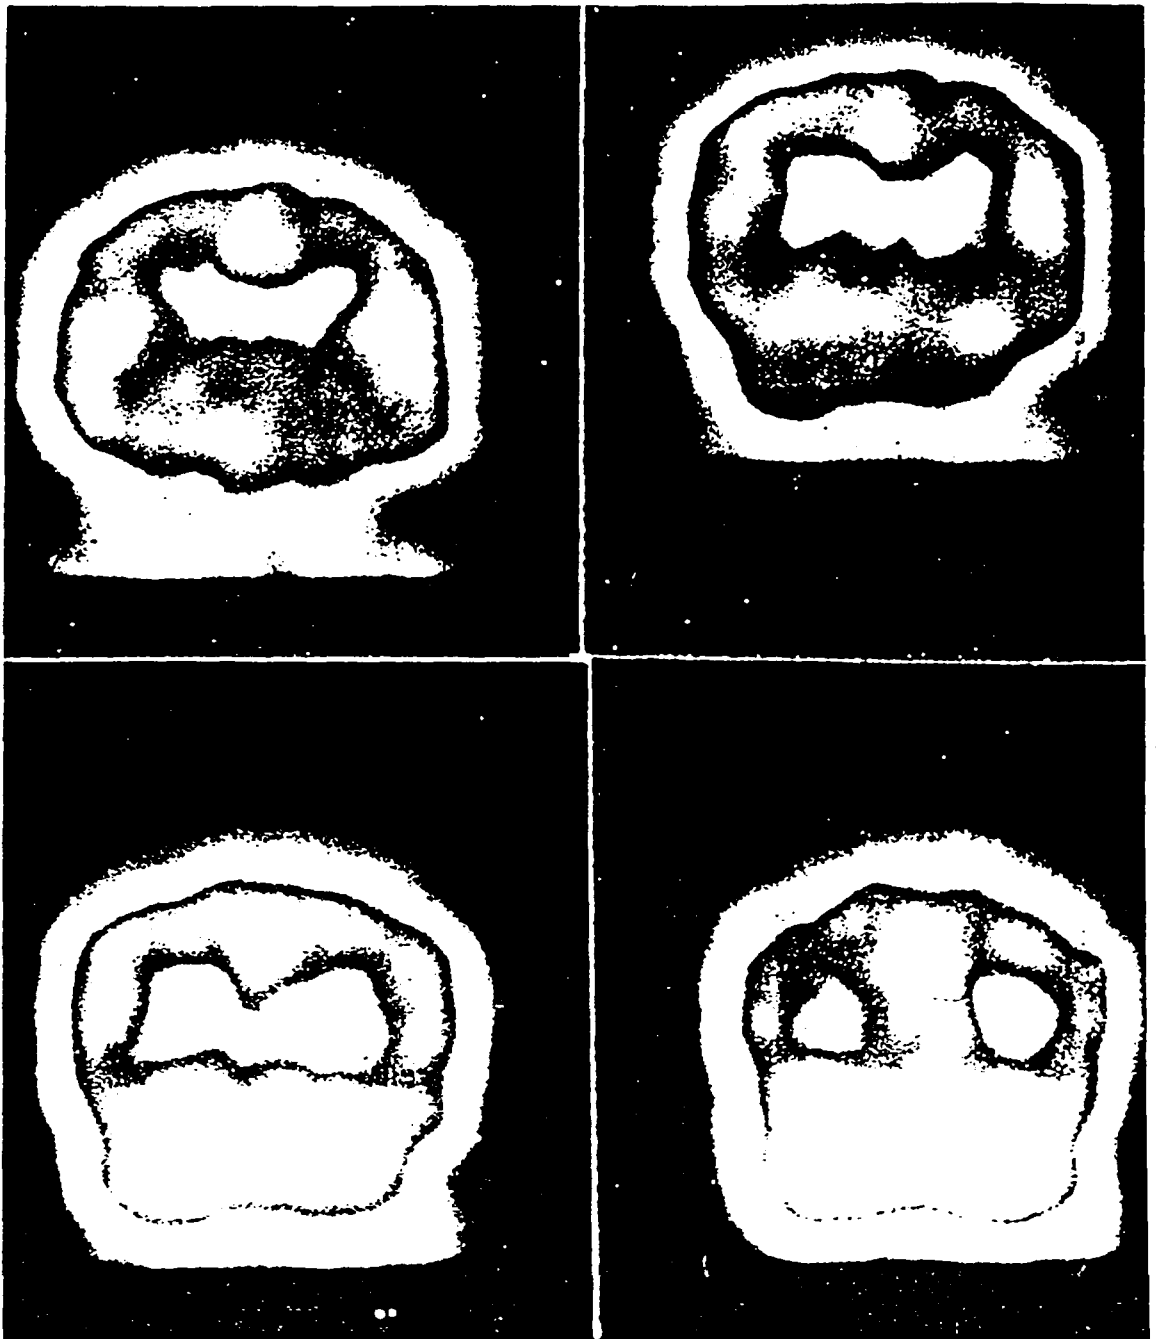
B. shows normal HMPAO ^{99m}Tc SPECT STUDY in Coronal sections. Note homogenous distribution of ^{99m}Tc HMPAO, and separation of grey matter and white matter perfusion.
